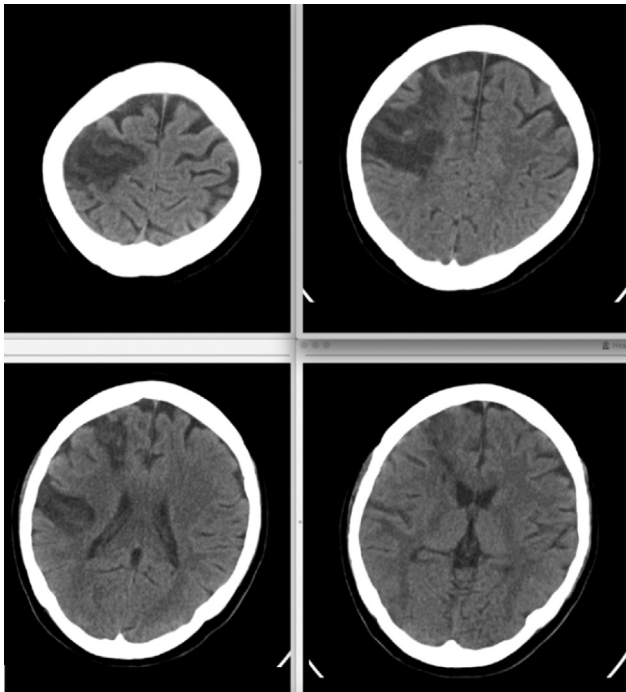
Computed tomography brain (plain) showing acute right middle cerebral artery infarct.
